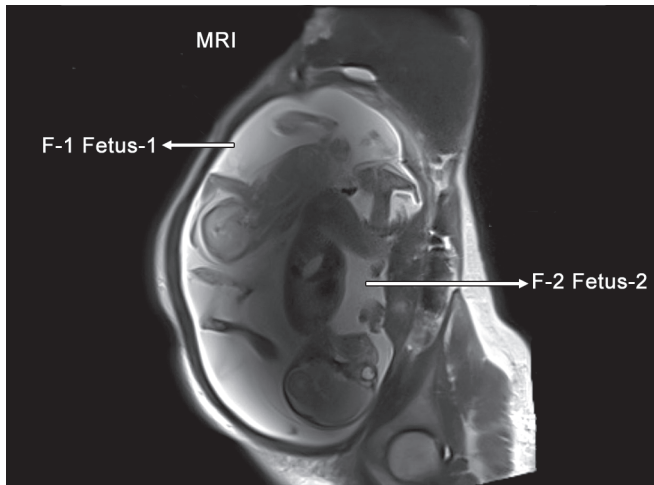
MRI image showing two of the three live fetuses (case 3)
